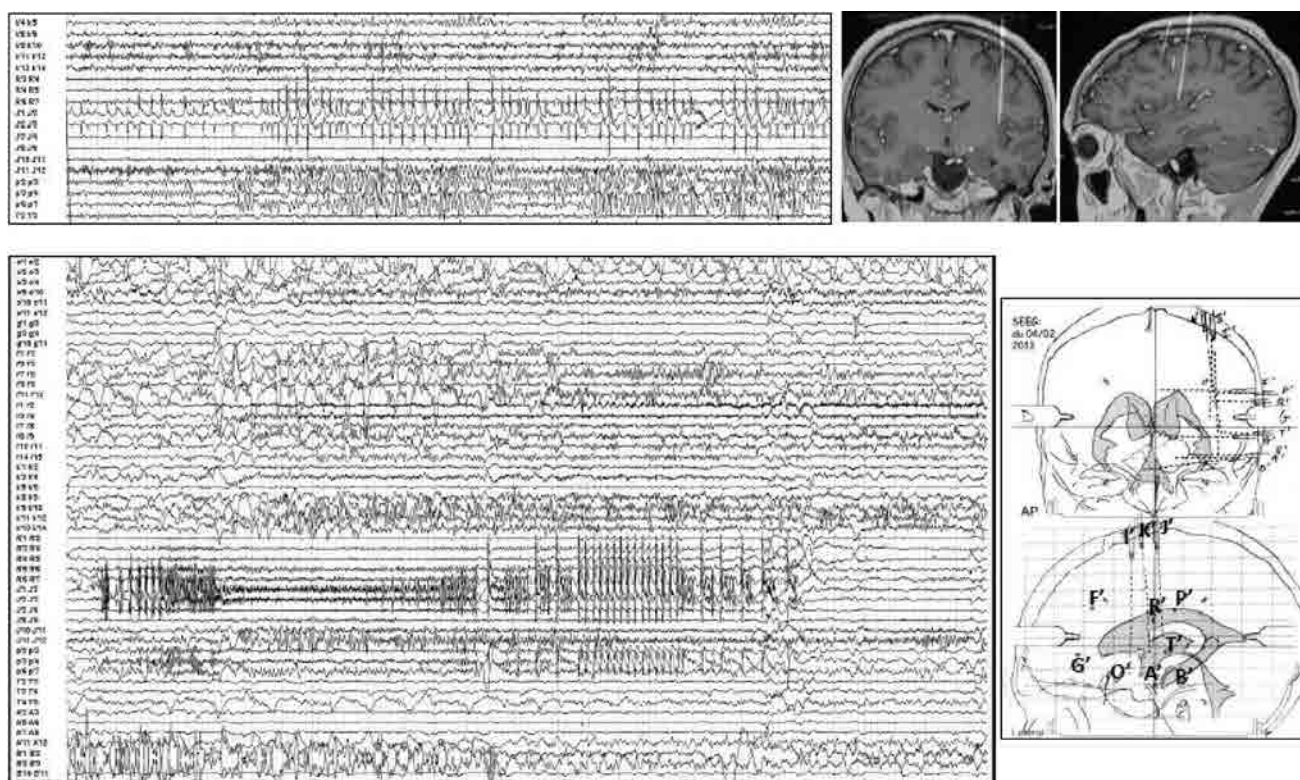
Insular epilepsy, negative MRI case. According to the electroclinical semiology, sampling involved the left insulo-perisylvian region with 6 electrodes in the insula (3 oblique [I', J', K'] and 3 orthogonal [R', P', T'] also covering by the lateral contacts the frontal, parietal and temporal opercula. Other electrodes in frontal lobe sampled the orbitofrontal [O'] and anterior cingulate cortex (mesial part of [G']), the inferior frontal gyrus (lateral part of [G']) and middle frontal gyrus [F']. In temporal lobe, two additional electrodes were placed (amygdala [A'] and hippocampus [B']), both of them recording the middle temporal gyrus by the lateral contacts). In the upper part, see the subcontinuous rhythmic spiking activity recorded interictally, well-localized on two contacts of the electrode [J'], highly suggestive of focal cortical dysplasia. Note the normal activity of closed electrodes [P', K']. In the lower part, ictal discharge started on the same area, with a burst of high amplitude spikes and rapid rhythms followed by a low voltage fast activity diffusing to adjacent electrodes [I', P', R']. The patient has been seizure free for 3 years after focal insular thermocoagulations.
